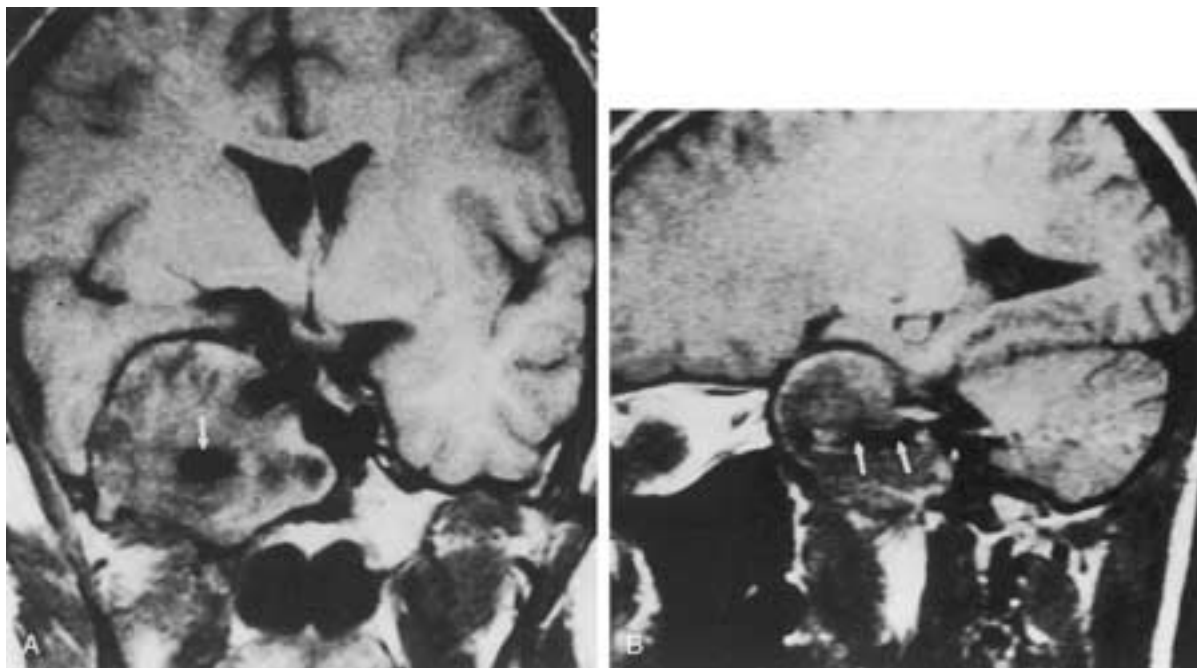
A, Coronal T1-weighted MR image. Partially thrombosed aneurysm of the petrous and cavernous carotid arteries. The flow void (*arrow*) is seen in the central part of the aneurysm. Most of the “mass” is filled with thrombus of varying signal intensities. B, Sagittal T1-weighted image without contrast again shows the flow void of the central lumen (*arrows*) within the larger mass, which is partially thrombosed.
